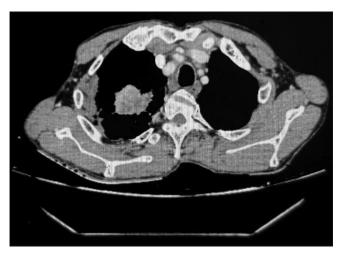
Contrast-enhanced computed tomography chest showing macro lobulated lesion with necrotic areas and multiple heterogeneously enhancing lymph nodes
